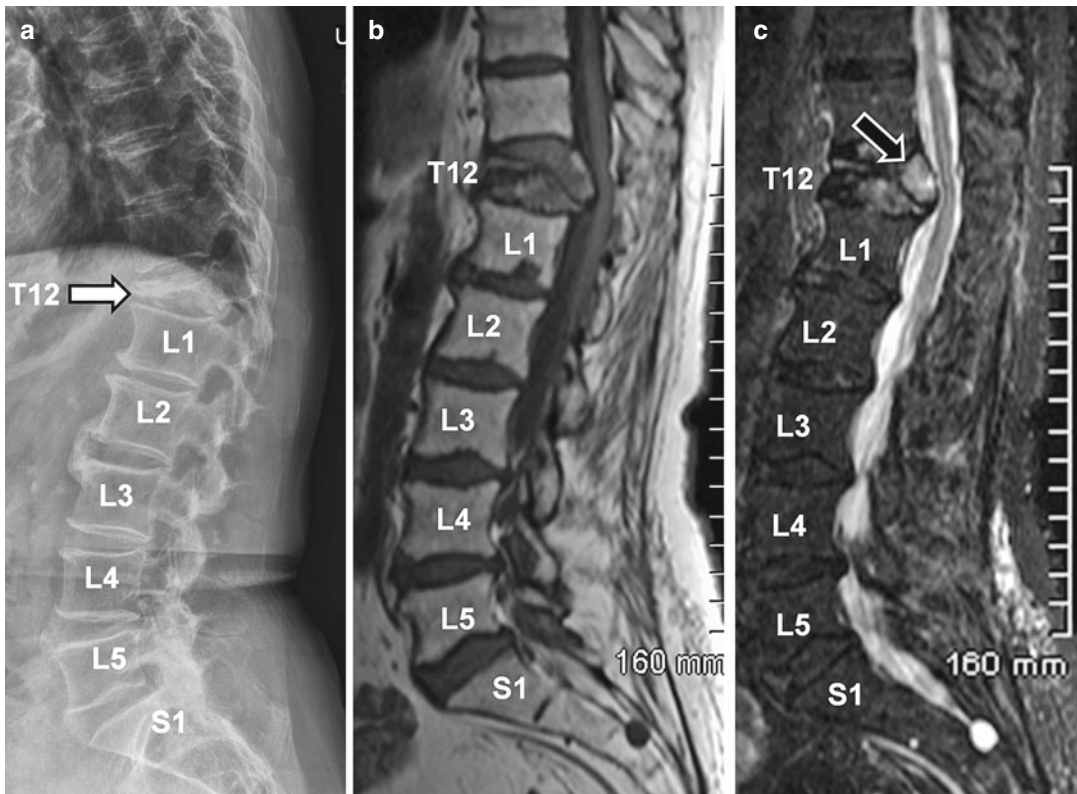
An 85-year-old woman presents to urgent care clinic following a fall from standing 2 days prior. (a) Lateral radiograph of the thoracolumbar spine demonstrates severe compression deformity of T12 (black arrow) with resultant kyphosis surrounding the fracture. Sagittal T1 (b) and sagittal short-tau inversion-recovery (STIR, c) images demonstrate the severe compression of the T12 vertebral body and the high signal indicative of fracture
